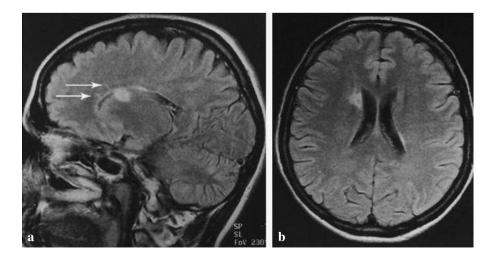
Brain MRI: a) Sagittal FLAIR image showing one large demyelinating lesion, as well as smaller lesions localized in the corpus callosum (arrows); b) transversal FLAIR image showing a large periventricular lesion.
